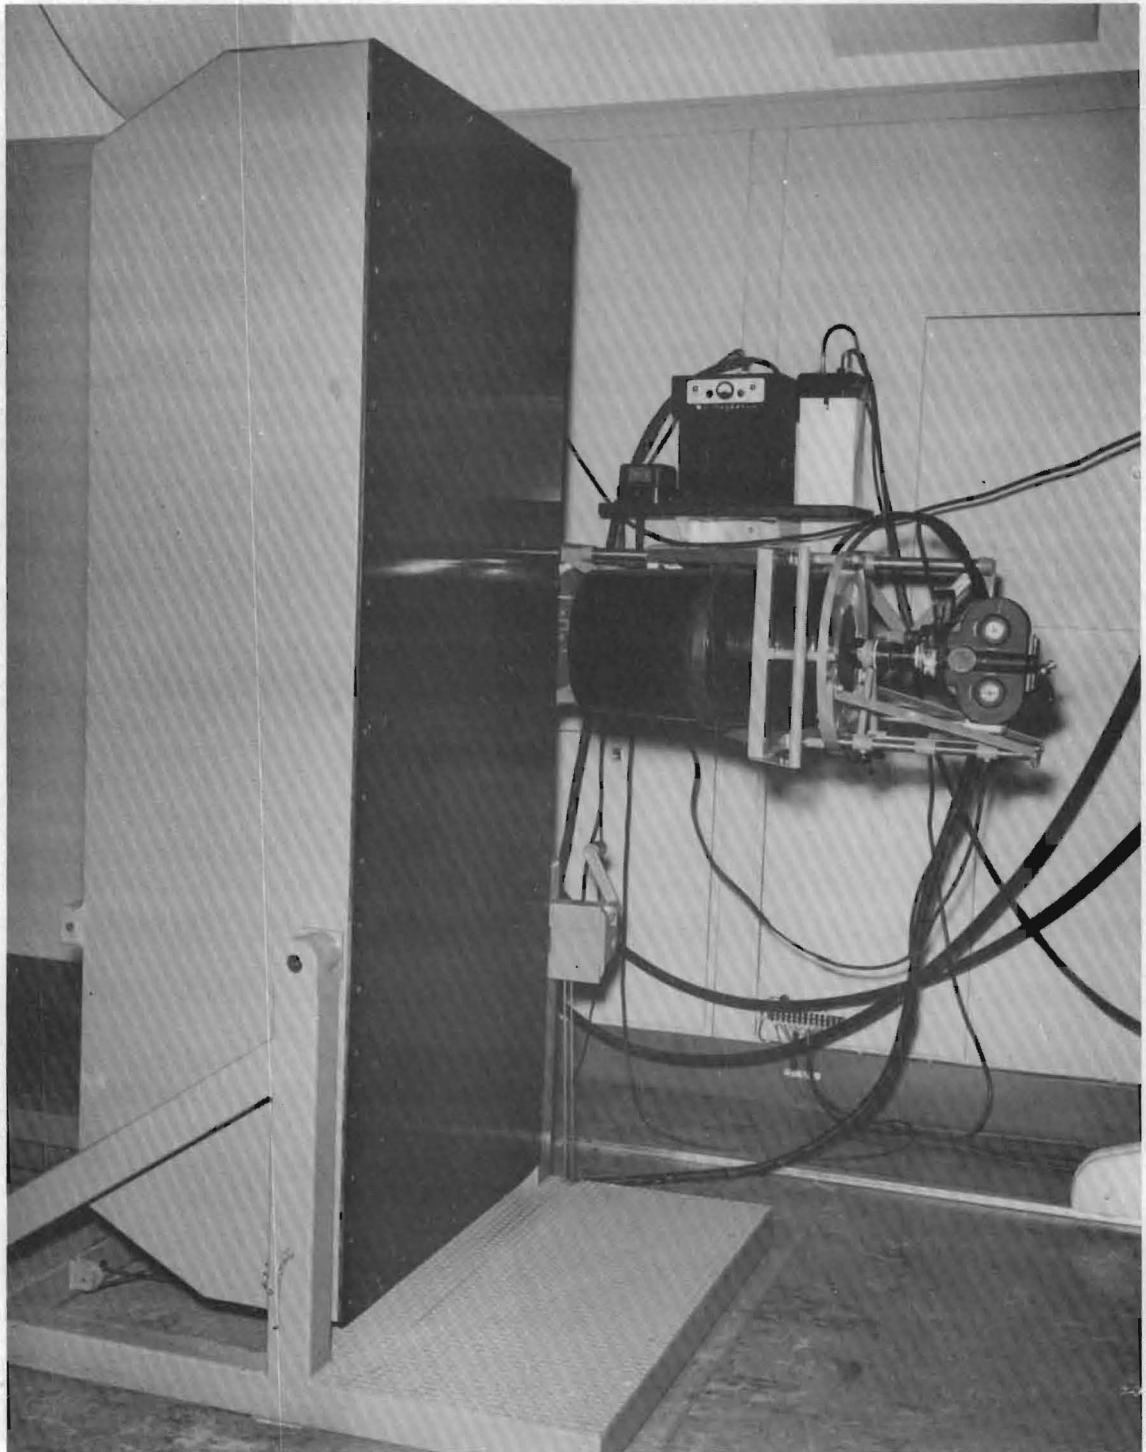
View of the Special X-Ray Table in a Vertical Position.
